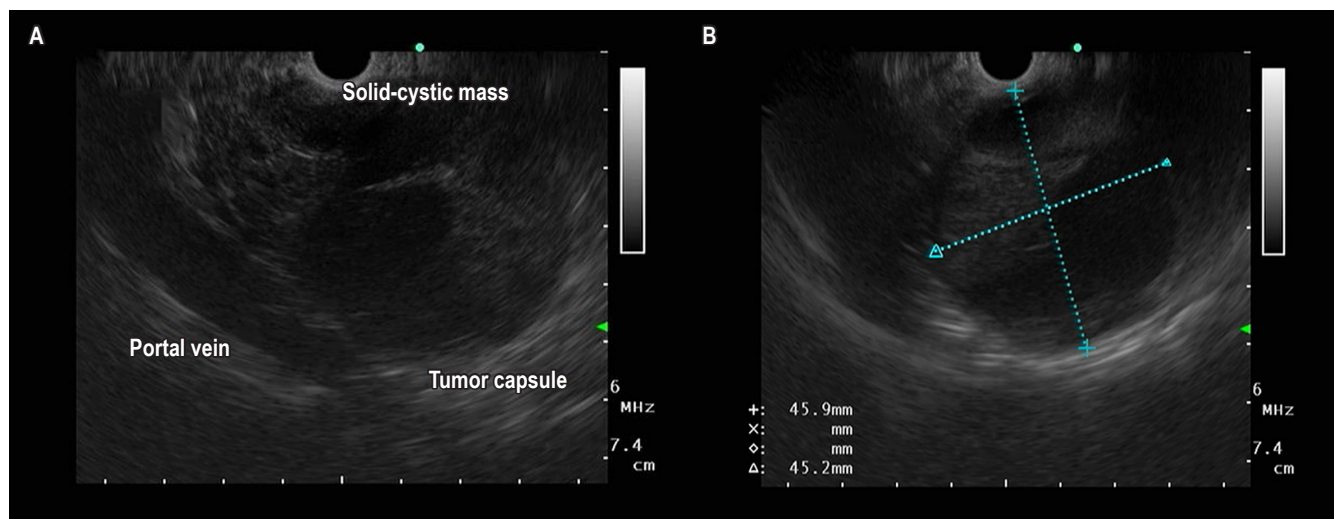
Pancreatic endoscopic ultrasound showing a solid-cystic mass in the head of the pancreas, well defined with a thick capsule. Images property of the authors.
